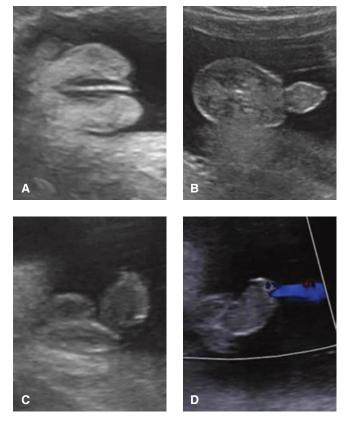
Normal and ambiguous genitalia. A. Female labia. B. Male penis and scrotum. C. Ambiguous genitalia with a phallus and bifid scrotum. D. With this condition, color Doppler can assist locating the urethral meatus, which is pinpointed here by the urine stream (*blue*).
